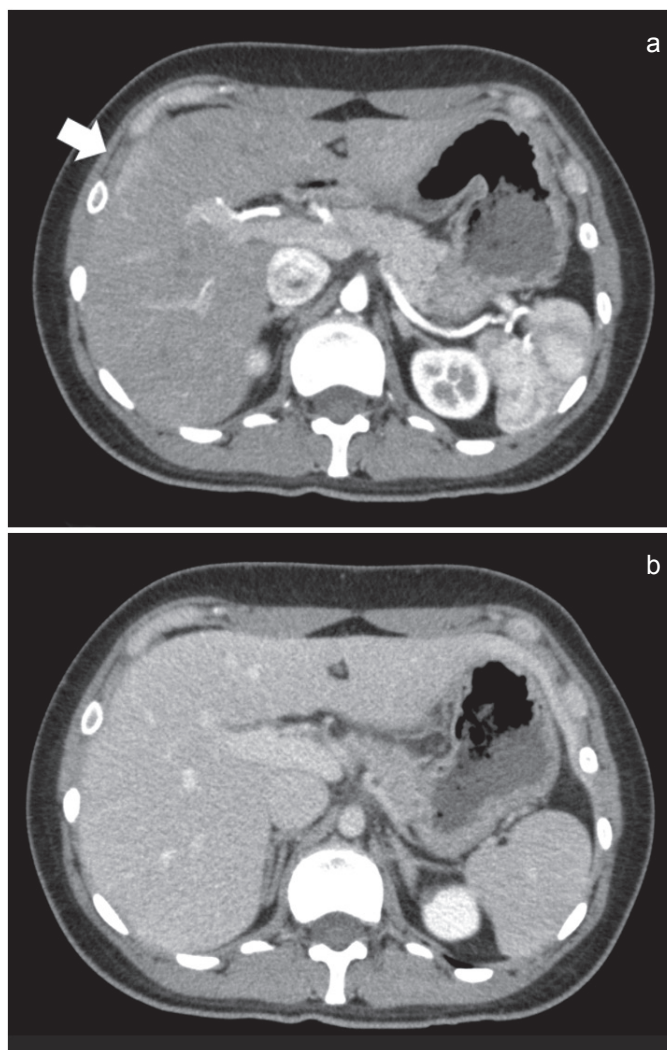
Computed tomography scan demonstrating partial hepatic capsule enhancement in the arterial phase (a, arrow) and inconspicuous enhancement in the venous phase (b) in the right lobe of the liver.
